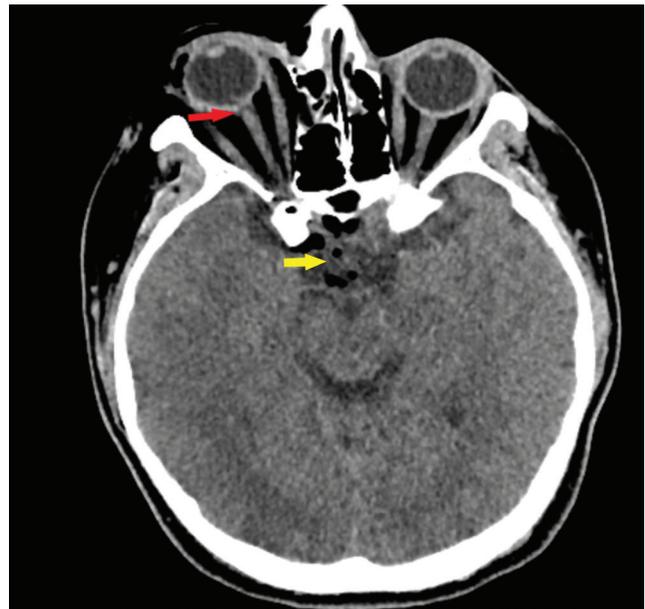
Initial computed tomography scan showing optic nerve avulsion (red arrow) without rupture of the optic nerve sheath and posttraumatic pneumocephalus (yellow arrow)
